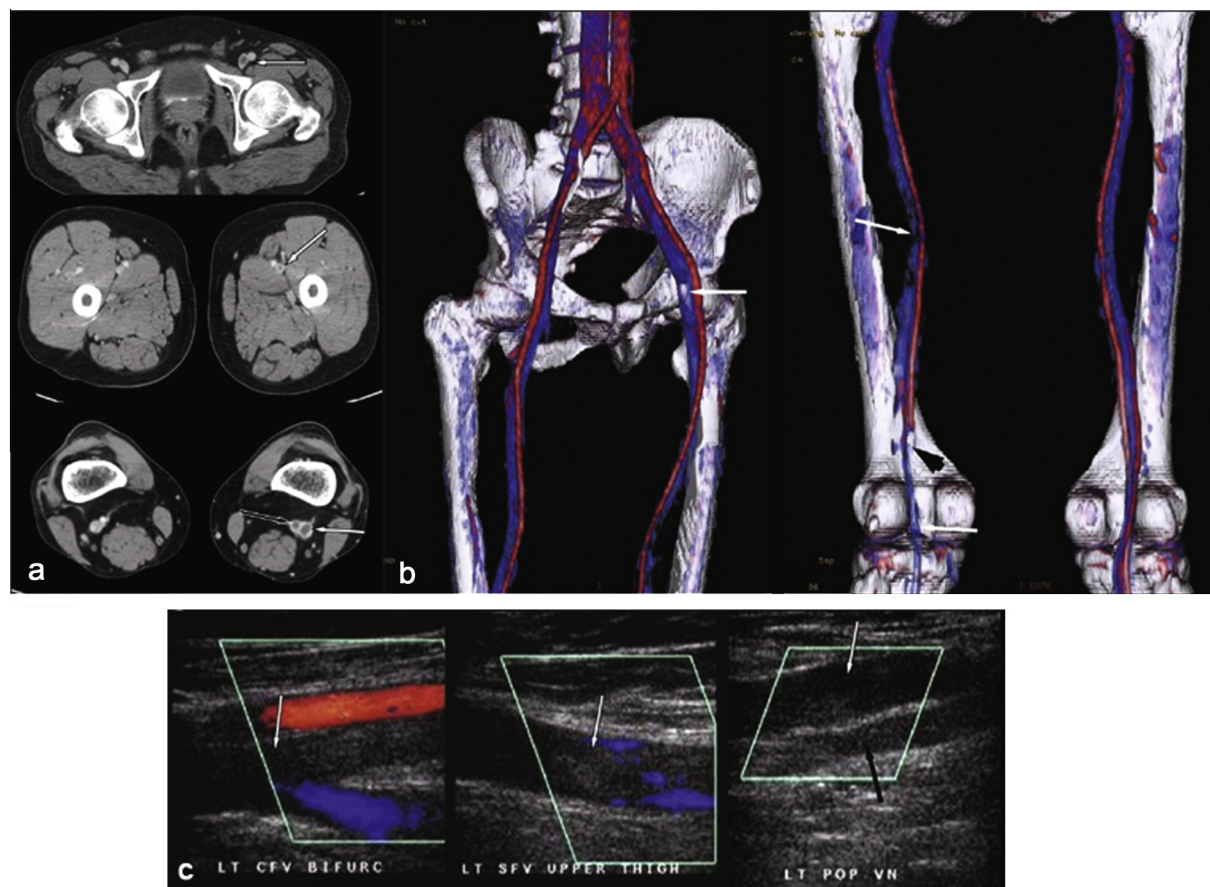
CTV and Doppler of lower limbs (a) CTV axial sections at level of upper thigh, mid thigh and popliteal fossa showing thrombus involving left common femoral vein, superficial femoral vein and popliteal vein (white arrows). In addition, thrombus is also seen in left popliteal artery (black arrow) (b): Volume rendered images in anterior and posterior view in the same patient showing filling defect in the region of left common femoral vein, superficial femoral vein, popliteal vein (white arrows) and left popliteal artery (black arrow) (c): Doppler USG of same patient at level left upper and mid thigh, and popliteal fossa showing thrombus filling left SFV and popliteal vein with absence of color filling. Left popliteal artery (black arrow) also showed no color fill in (thrombus) [26].
